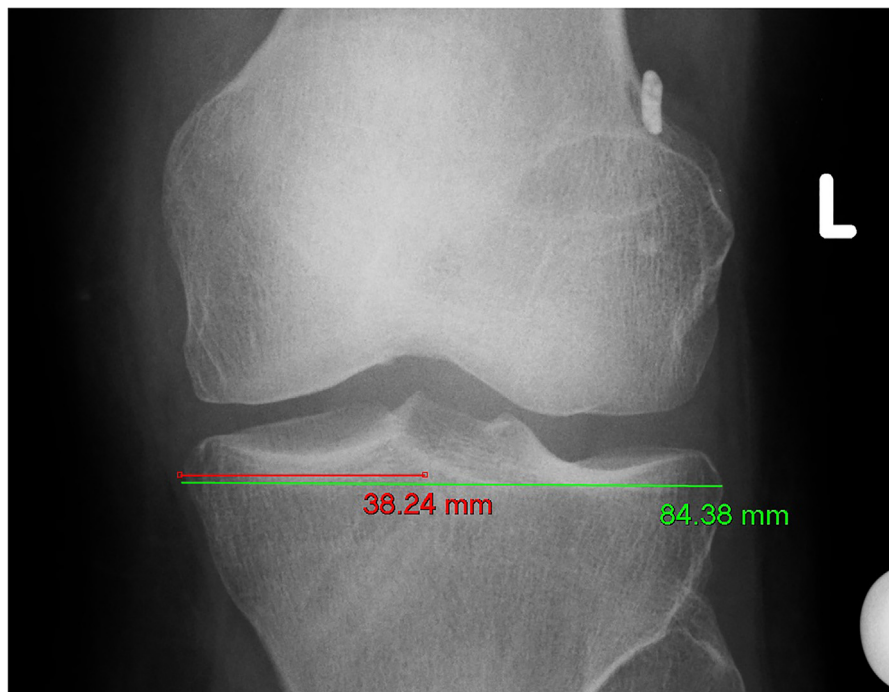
Anteroposterior radiograph of the knee showing method of measuring tunnel position. Red line: distance of tibial tunnel from medial aspect of tibia, Green line: width of tibial plateau. Medial to lateral tunnel position = 45.3%.
